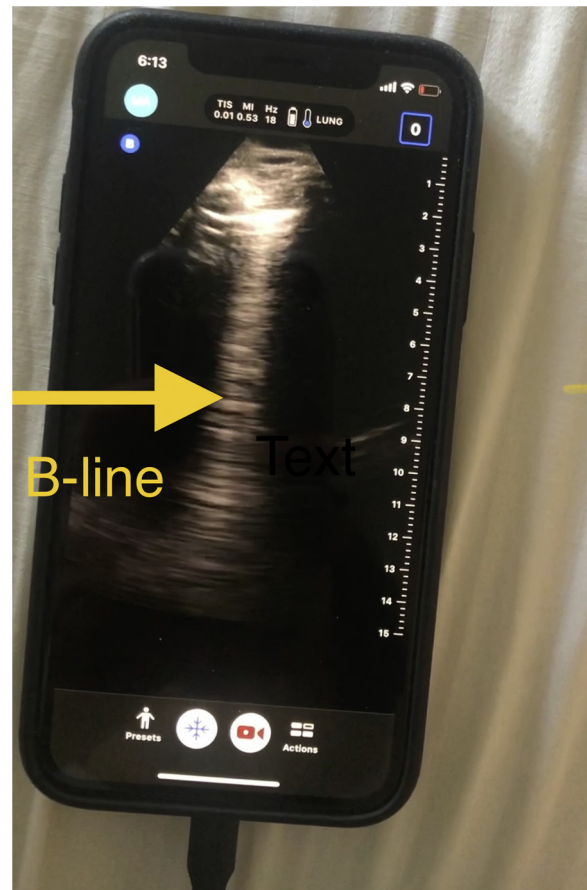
Non-confluent B-line seen in the right posterior lung field, a common ultrasound finding in COVID-19 infection.
